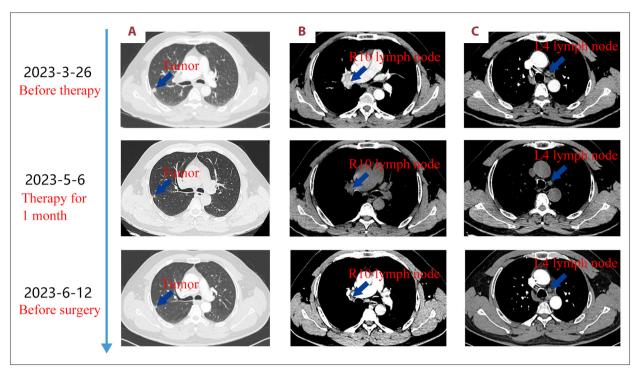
Timeline of CT examinations before surgery. (A) On the first CT before therapy, a solid nodule was found in the right upper lobe, measuring approximately 10×9 mm, with irregular margins. Enlarged R10 and L4 lymph nodes were also found in the mediastinum. (B) One month after neoadjuvant therapies, CT showed decreased size of the nodule beneath the pleura (from 10×9 mm to 5×4 mm) and reduced size of R10 and L4 lymph nodes. (C) Two months after neoadjuvant therapies but before surgery, CT showed the nodule beneath the pleura had remained the same size (5×4 mm) and the lymph node had decreased in size (from 28×18 mm to 17×16 mm).
